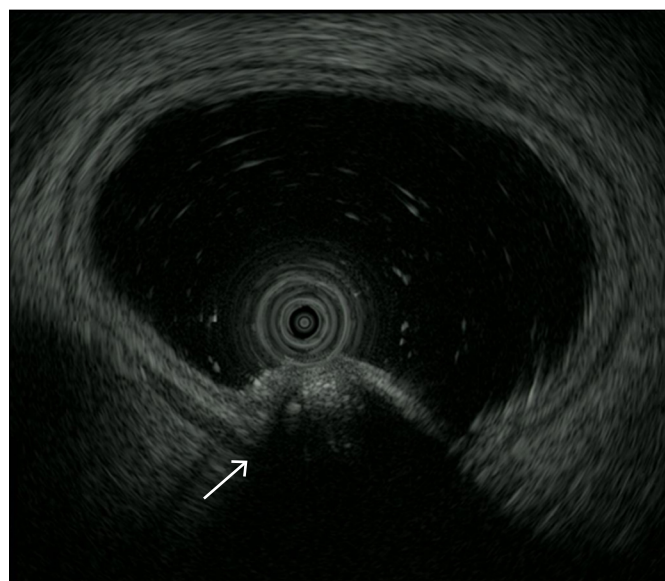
Endoscopic ultrasonography showing a homogeneous hypoechoic lesion and continuity between the tumor and the muscularis layer (arrow).
